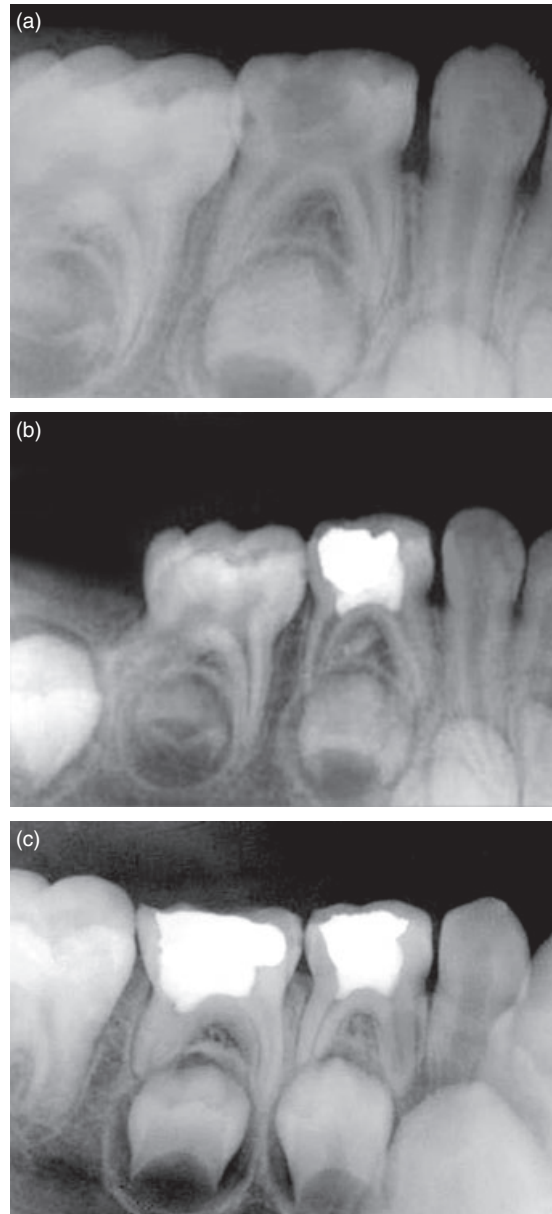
(a) Initial radiographic feature of successful pulpotomy with MTA. (b) Radiographic feature of successful pulpotomy with MTA after 3 months. (c) Radiographic feature of successful pulpotomy with MTA after 6 months.
